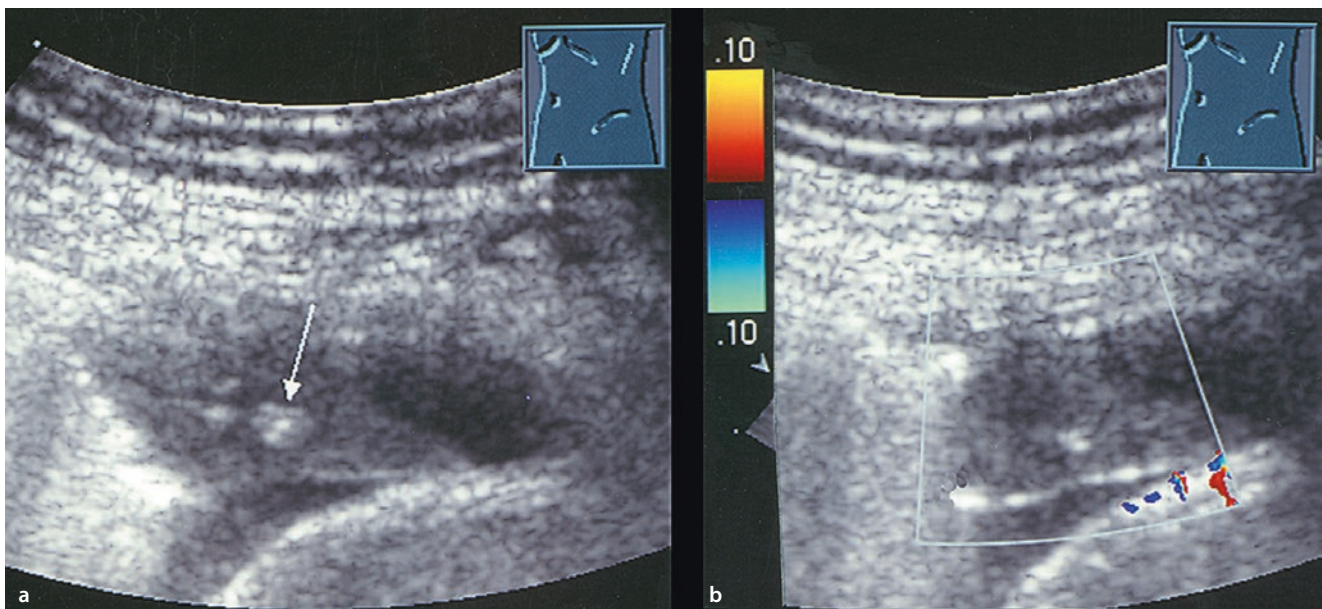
A 43-year-old man with a lung infarction. a On the B-mode image one finds a hypoechoic wedge-shaped lesion with a central bronchial reflex (arrow). b Color-Doppler sonography shows the absence of vascularization
